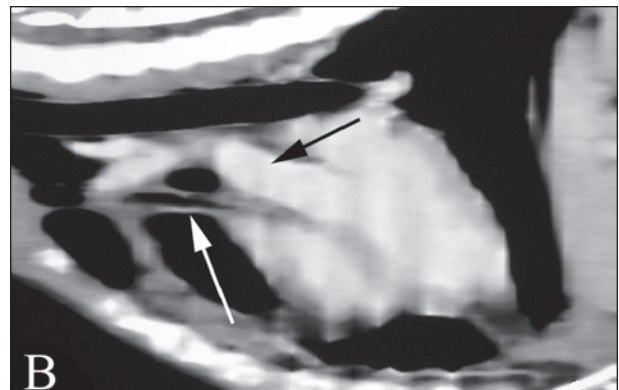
Transverse contrast-enhanced computed tomographic image of the cranial portion of the mediastinum (A) and sagittal plane reconstruction computed tomographic image displayed in a mediastinal window (B). Notice the hypoattenuating wooden foreign structure surrounded by soft tissue-attenuating fibrous tissue (white arrow) ventral to the cranial vena cava (arrowhead), extending caudally to the aortic arch (black arrow).
